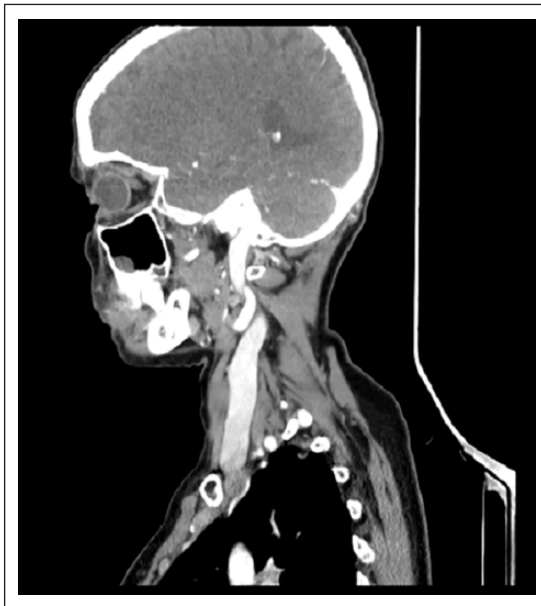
Sagittal contrast-enhanced CT image of the neck showing a well-defined large saccular internal jugular vein.
